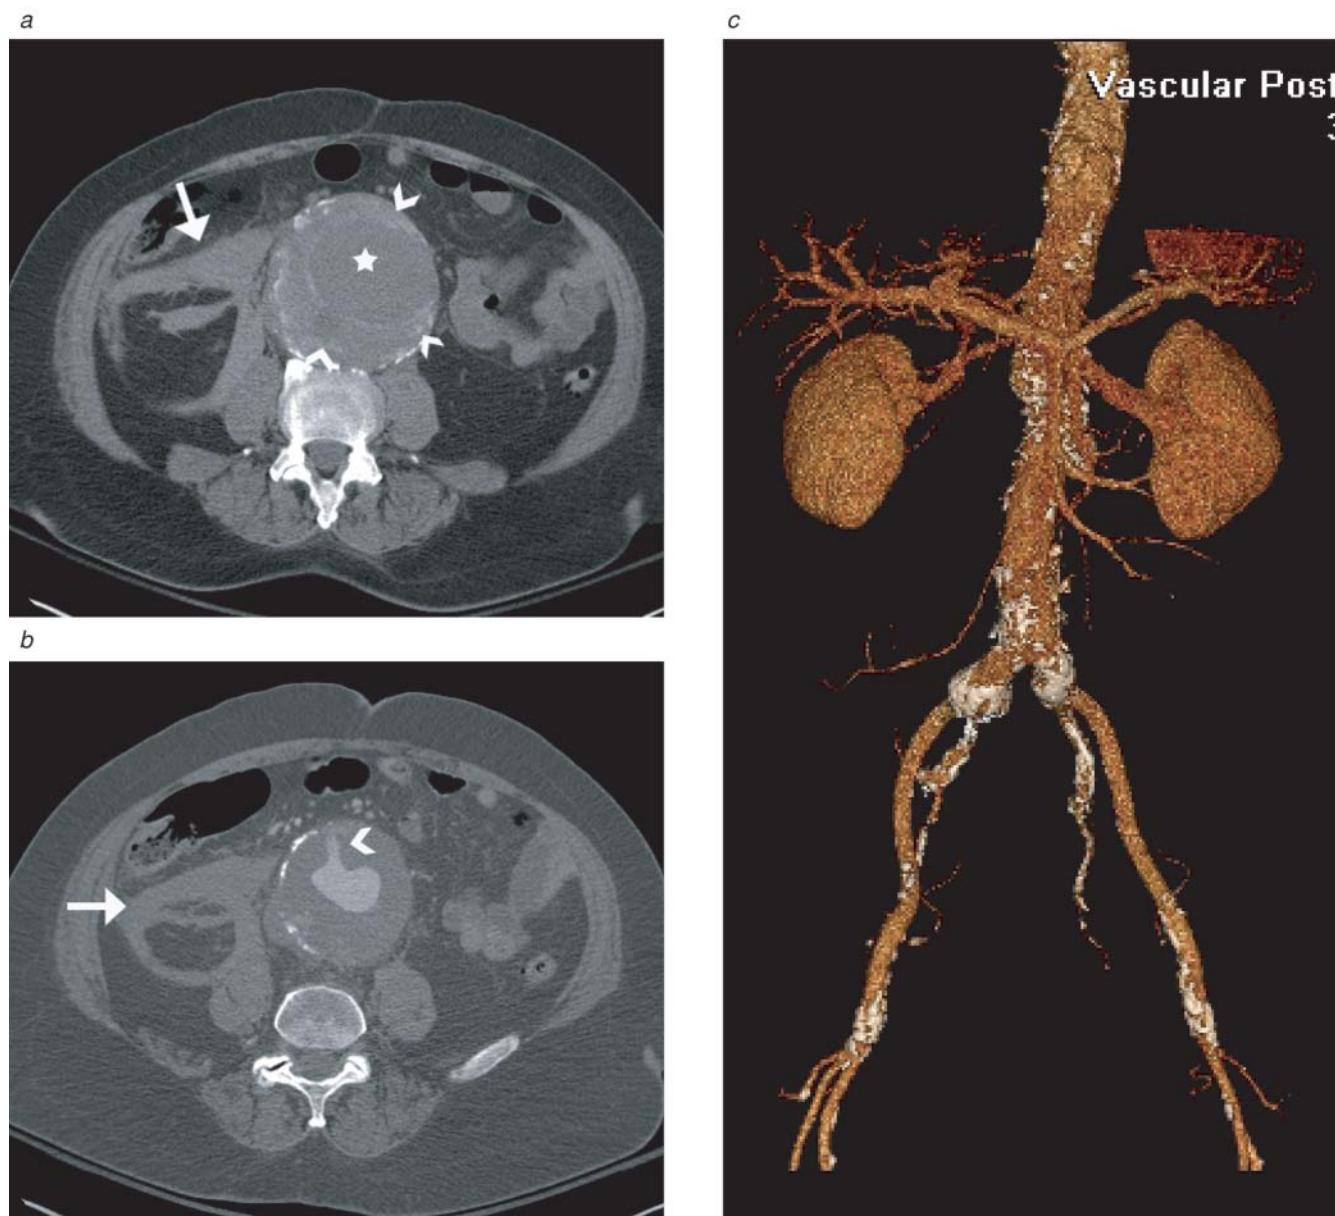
An 81-year-old male presented to the emergency department with acute onset of severe back pain and an episode of collapse. (a) An axial noncontrast computed tomographic scan demonstrates a large infrarenal abdominal aortic aneurysm (star) with evidence of retroperitoneal hemorrhage (arrow). Note the high-attenuation material (arrowheads) within the thrombus of the aneurysmal sac consistent with acute hemorrhage into the thrombus-filled sac. (b) Following administration of intravenous contrast, there is evidence of jets of contrast into the thrombus within the aneurysmal sac (arrowhead) and high attenuation within the retroperitoneal hemorrhage (arrow). These findings are consistent with rupture of the infrarenal aneurysm. (c) This was successfully treated by open repair, as shown by this volume-rendered multidetector computed tomographic angiogram postrepair.
